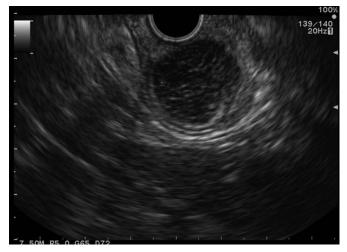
Endoscopic ultrasonography revealed a heterogeneous hypoechoic mass in the submucosa.
